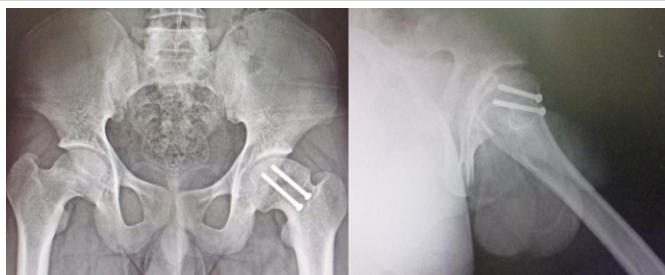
(a and b) Follow-up radiographs of 30 months showing fused physis, no signs of avascular necrosis.
